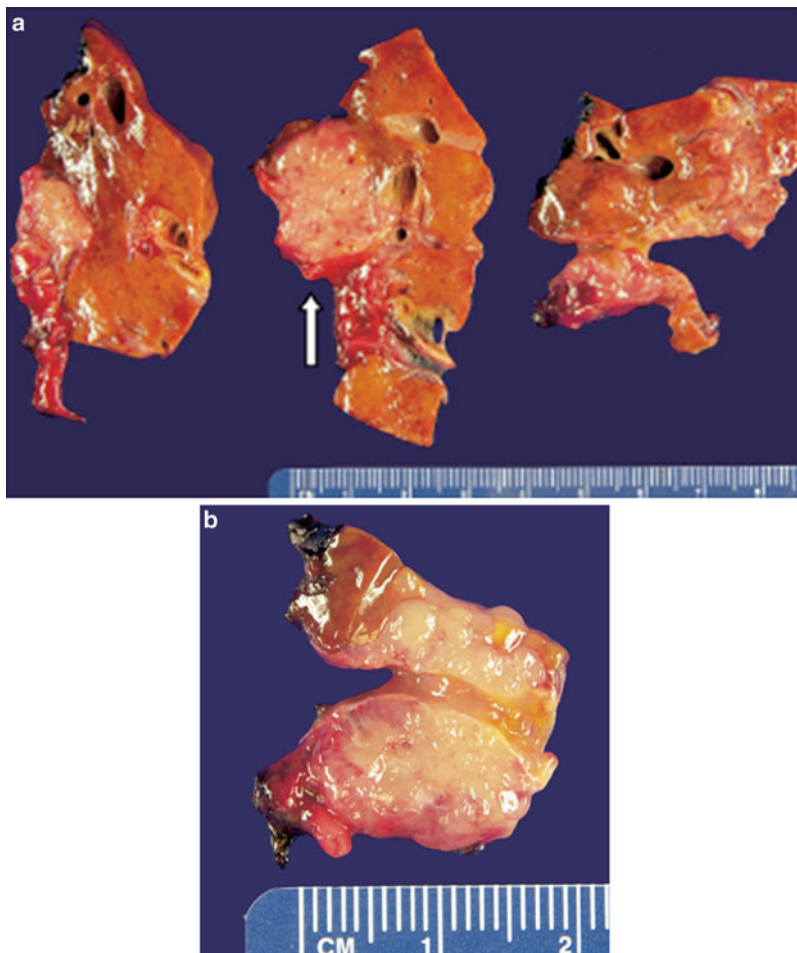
Shown are photos of a right trisegmentectomy with biliary carcinoid (a) involving the bile duct with extension to periductal soft tissue (b); adapted with permission from [21]. The patient is a 52-year-old male with coronary artery disease s/p coronary artery bypass in 1999 noted to have elevated liver function tests on routine blood work, including an alkaline phosphatase of 289 U/L (33–88 U/L), an aspartate aminotransferase of 67 U/L (10–37 U/L), and an alanine aminotransferase of 85 U/L (5–37 U/L). Physical examination was unremarkable. Liver ultrasonography demonstrated right-sided biliary dilation terminating in a mass arising from the right hepatic duct, consistent with a papillary cholangiocarcinoma. A magnetic resonance cholangiopancreatogram confirmed this finding and showed no evidence of metastatic disease. Additionally, there was no evidence of portal vein involvement or hepatic lobar atrophy. Endoscopic retrograde cholangiogram, performed before referral, demonstrated a mass completely obstructing the right hepatic duct, with a normal left biliary system and common bile duct. Clinically, the patient was well, had no jaundice or pruritus, and denied any symptoms related to the biliary tumor. The patient was taken to the operating room in June 2006 with a presumptive diagnosis of hilar cholangiocarcinoma. The operative findings were consistent with a proximal biliary cancer, confirming the preoperative imaging data. A right trisegmentectomy, common bile duct resection, and portal lymph node dissection were performed. Macroscopically, the tumor appeared as a 2.2-cm homogeneous tan lesion arising from the right hepatic duct and extending into the hilar soft tissue and hepatic parenchyma as shown in panels a and b
